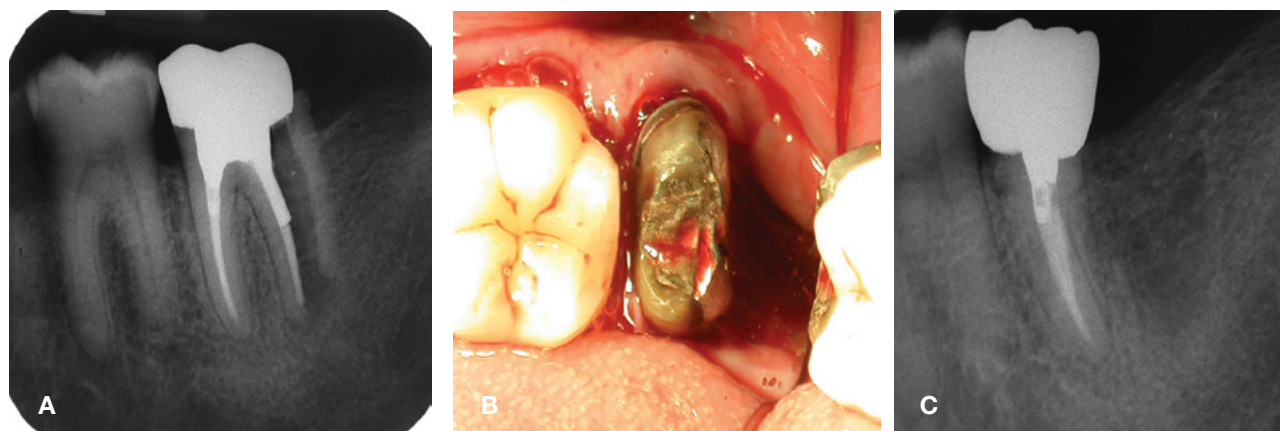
(a) Pre-op radiograph #18, showing distal root fracture. (b) Post-op showing distal root hemisection. (c) 1 year recall showing complete healing. (Courtesy of Dr. Gary Matt)
